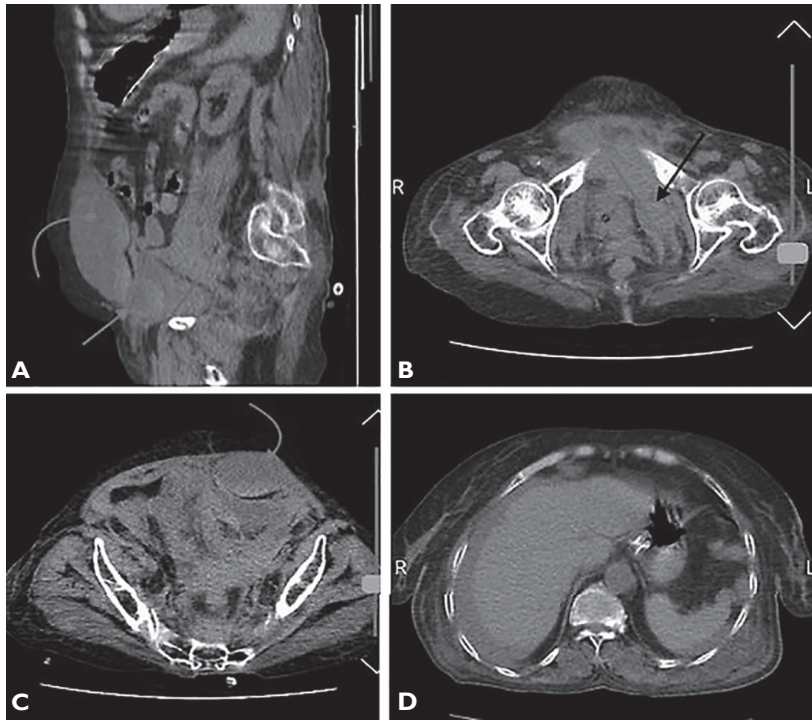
Abdominal/pelvic computed tomography scan without contrast showing intramuscular haematomas. A) Sagittal view showing hyperdense fluid collection in left rectus muscle in favor of haematoma (curved arrowhead) and smaller haematoma in extraperitoneal space (direct arrowhead) with adjacent hyperdense free fluid in peritoneal space (direct line). B) Axial view which shows enlargement and faint hyperdensity of left obturator internus muscle extended to infra and supra pubic space. C) Axial view revealing haematoma in left rectus (arrowhead) with adjacent free fluid in peritoneal space (direct line). D) Axial view showing free fluid in perihepatic and perisplenic spaces.
